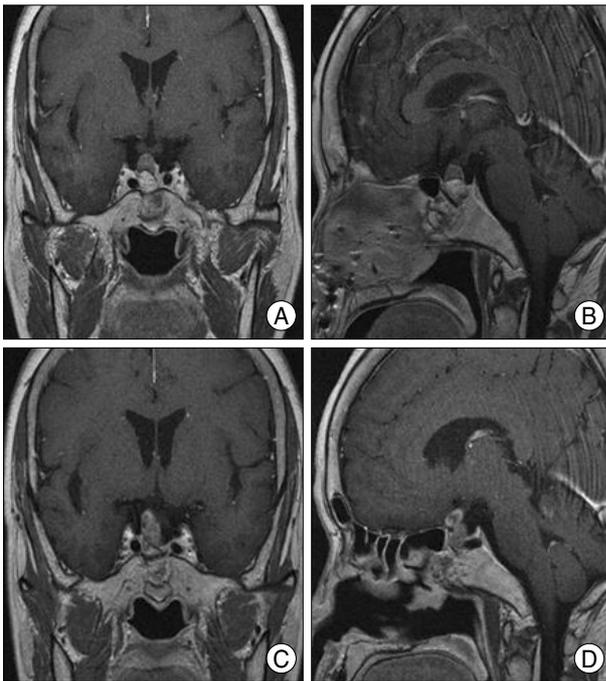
Magnetic resonance images obtained in case 5. Gadolinium enhanced coronal (A) and sagittal (B) MR images obtained 24 months after CyberKnife (CKRS), Gadolinium enhanced coronal (C) and sagittal (D) MR images obtained 40 months after CKRS showing aggravation of optic nerve involvement due to superior extension of pituitary adenoma.
